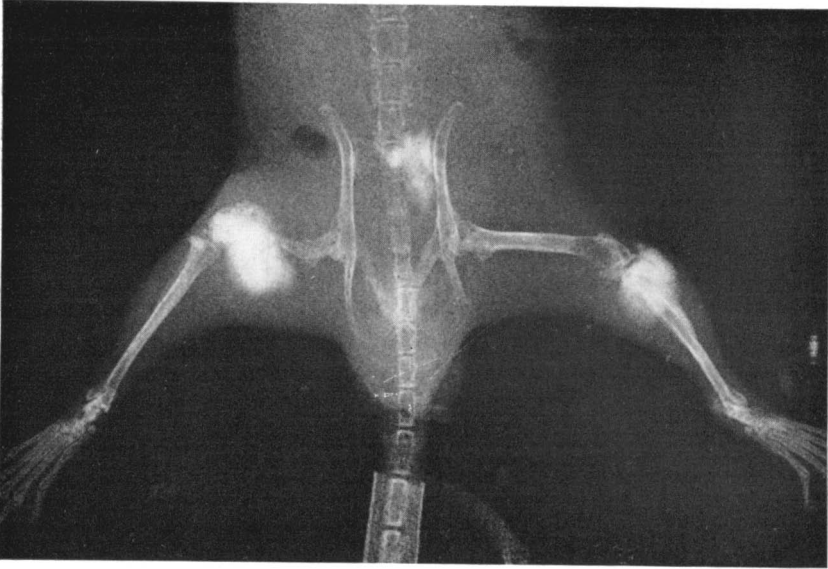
Roentgenogram of osteoblastic osteosarcomas 274 days after injection of Sr^{90} . Note also the lytic process in distal part of left femur.
